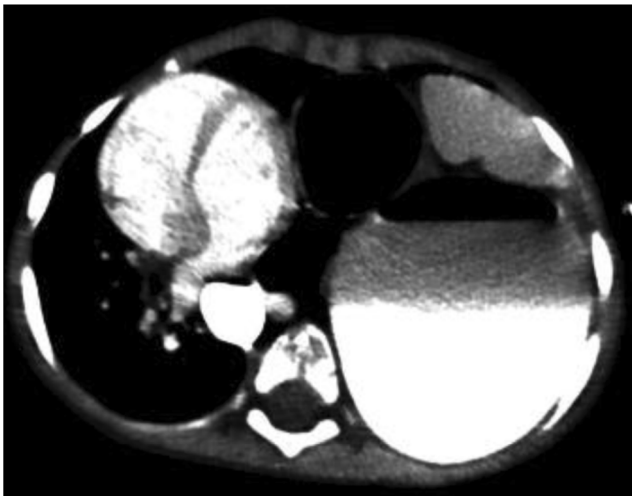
CT with oral and intravenous contrast shows the stomach and spleen in the left hemi-thorax.
